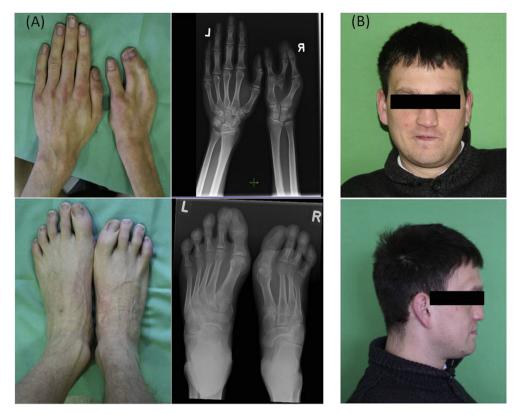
(A). Hands and feet of the patient 1. Note the oligosyndactyly of the right hand, with the hypoplasia of the distal ulna and radius and absence of the fourth and fifth metacarpals and fingers. The X-ray of the right hand revealed only four carpal bones that are partly fused, short metacarpals 1st, 2nd and 3rd, and bone syndactyly of the terminal phalanges of the 2nd and 3rd finger. The right foot was smaller and revealed the oligodactyly with the absence of the fifth toe and metatarsal bone. (B). Facial pictures of the patient 2. Note the high forehead, horizontal eyebrows, mild midface retrusion and a thin vermilion of the upper lip (upslanted palpebral fissures — covered).
